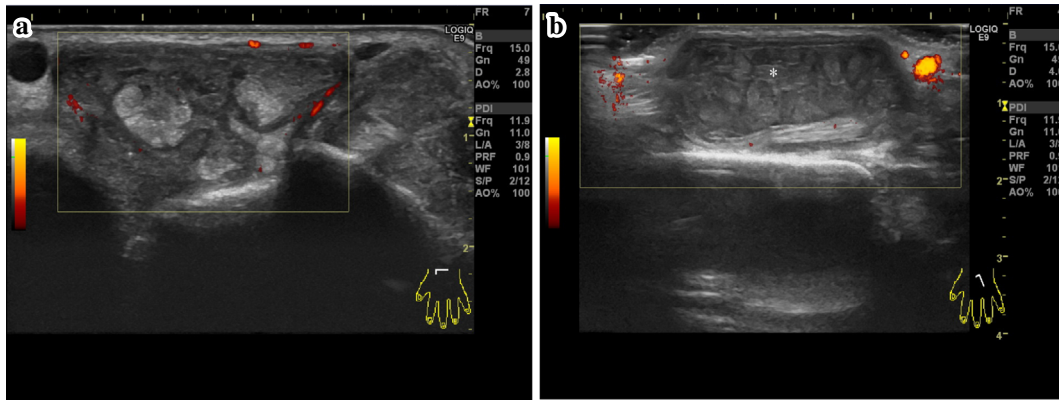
(a) Transverse musculoskeletal ultrasonography of the third and fourth compartments of the left wrist. The grayscale image shows a markedly thickened extensor tendon sheath, and power Doppler signals are detected in the margin of the tendon sheath. (b) The longitudinal view of the extensor tendon sheath. Multiple isoechoic rice bodies surround the tendon (white asterisk).
